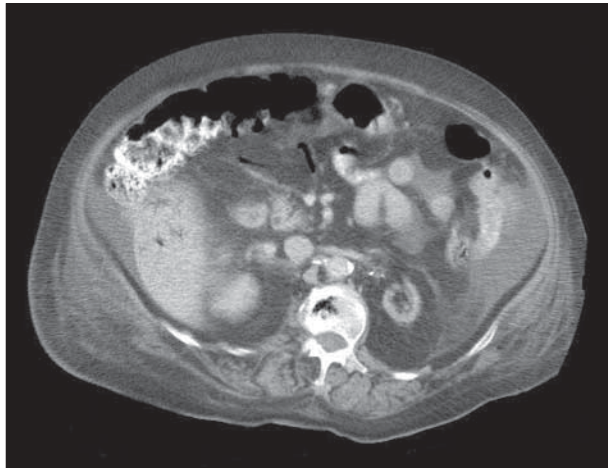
Abdominal computed tomography showing streaks of air in the bowel mesentery.
